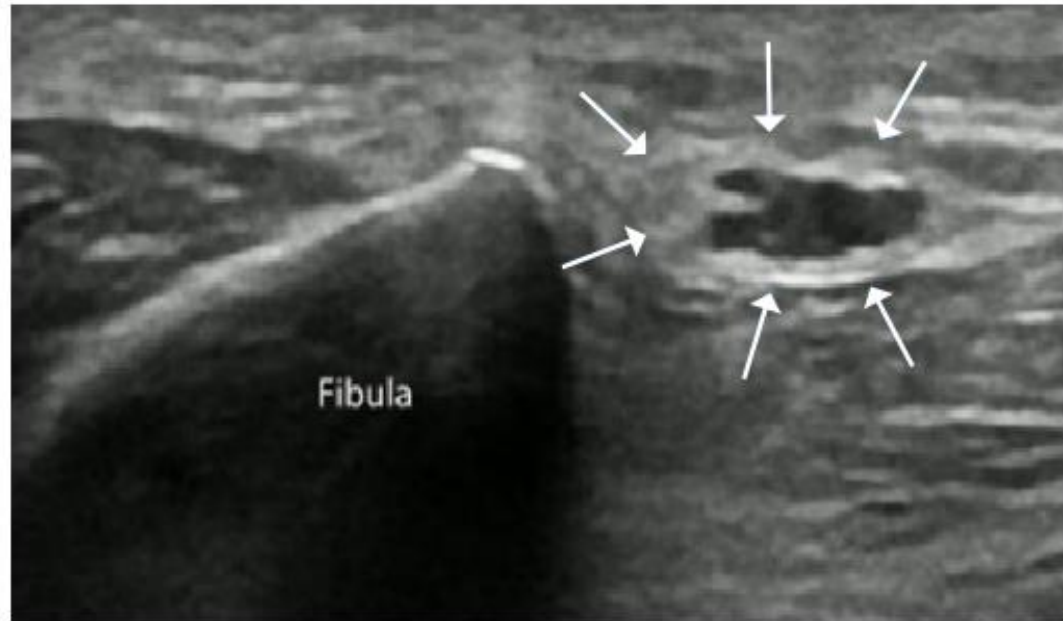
A 60-year-old patient presenting with foot drop and numbness in the lower extremity. On a ultrasonography examination, the common peroneal nerve (arrows) at the level of the fibular head shows swollen fascicles and a thickened perineurium.
